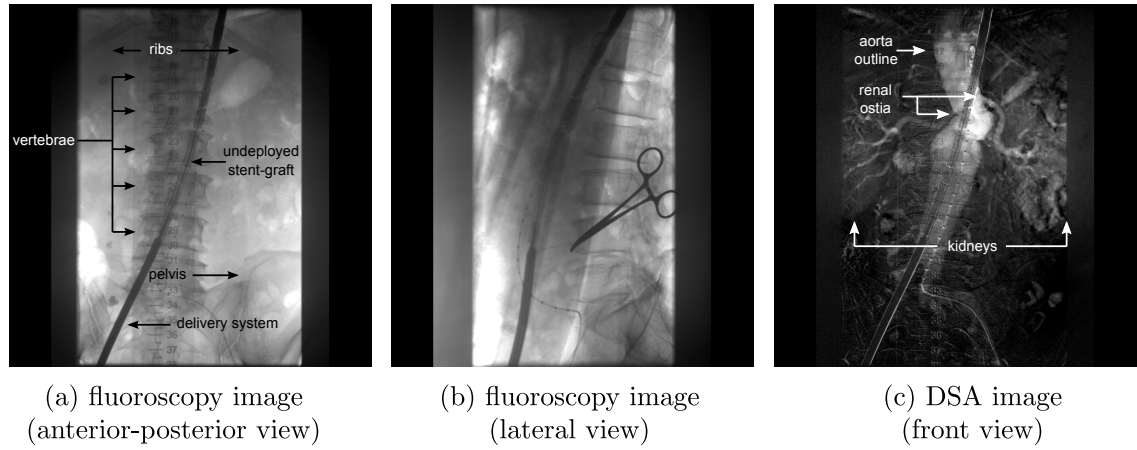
(a) X-ray image acquired from an anterior-posterior (AP) view. One can see the bony anatomy of the patient (vertebrae, ribs and pelvis) and instruments inside the aorta (delivery system with undeployed stent-graft) (b) X-ray image acquired at a similar point in time with a different position (lateral view) of the imaging system. The same structures can be seen from a different angle. (c) DSA image from an AP view. Information is shown on the aorta and the blood vessels connected to it and surrounding organs.
